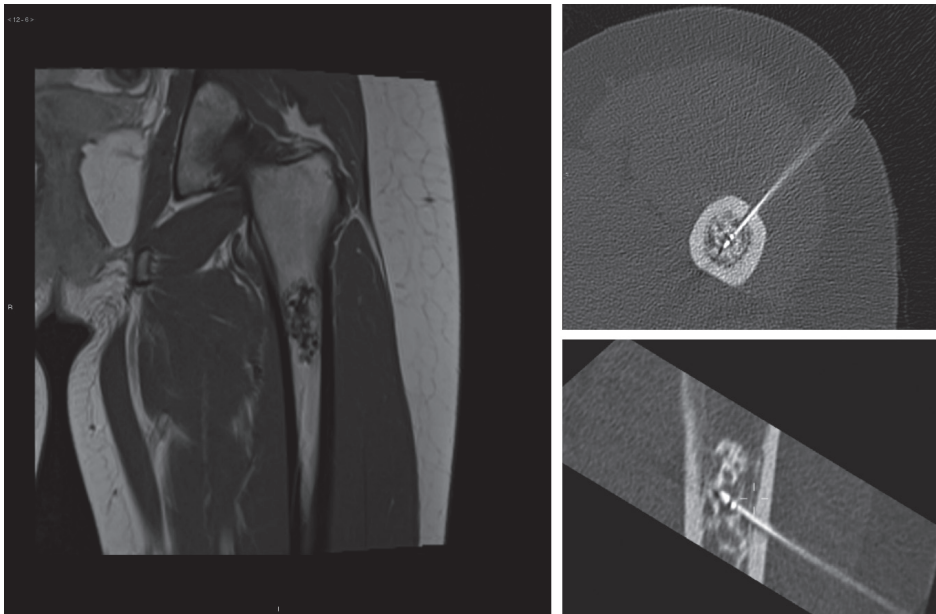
Representative MRI of atypical cartilaginous tumour (ACT) in the proximal femur
